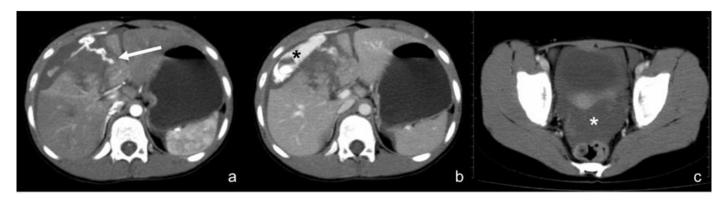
Contrast enhanced abdominopelvic CT. (a) Arterial phase image displays evident arterial extravasation of the contrast medium with the lacerated right hepatic lobe (arrow). (b) venous phase shows clear hyperdense hepatic subcapsular accumulation of contrast medium suggesting blood accumulating within the confined subcapsular space. (c) Large volume of hemoperitoneum within the pouch of Douglas confirming hepatic capsular rupture.
